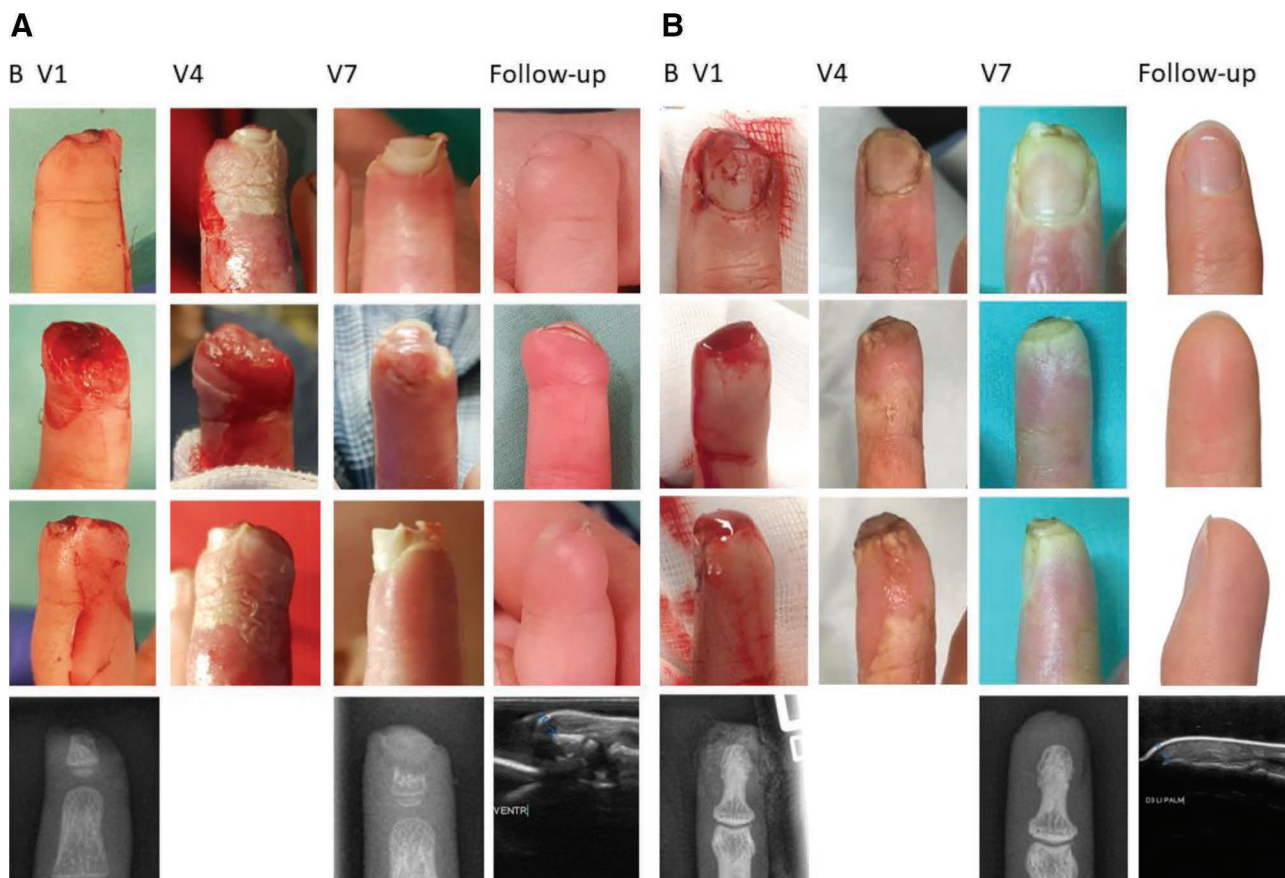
Photographs and radiographs/sonographies at the day of the injury (V1), at 2 wks (V4), at 4 wks (V7), and after more than 4 mo (follow-up). (A) Allen IV-injury, (B) Allen I-injury.
